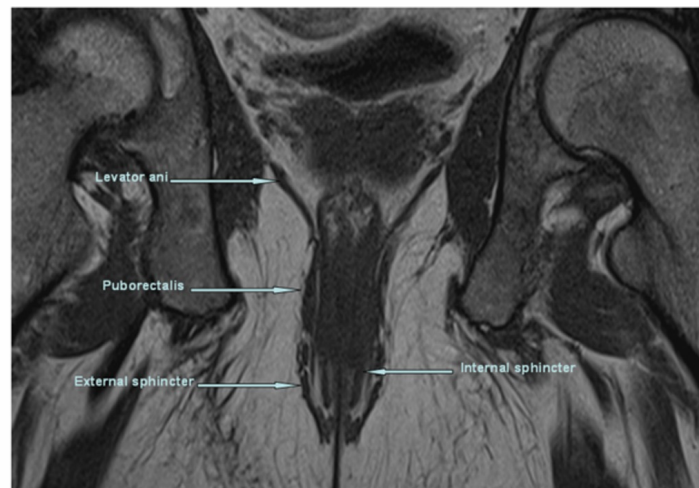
Coronal T1WI MRI, showing normal anal anatomy ⁽¹⁵⁾
